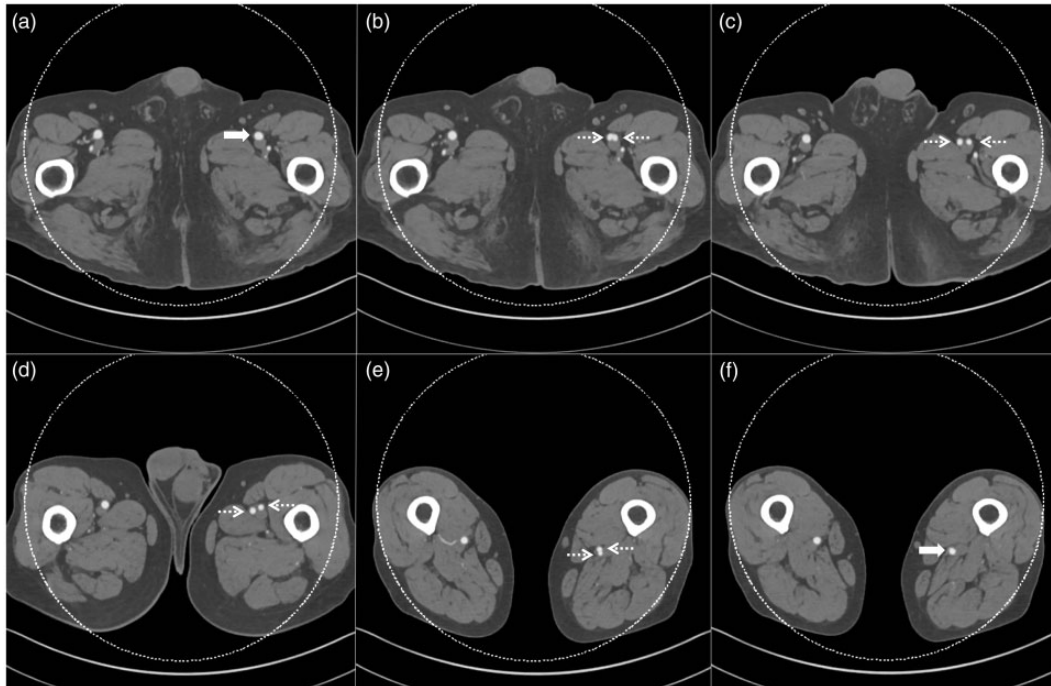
CTA of the lower limbs in the axial plane demonstrates duplication of the left SFA (dotted arrows) approximately 4 cm inferior to the CFA bifurcation. The duplicated SFA appears symmetrical in caliber although individually the vessel lumens are marginally smaller in caliber than the contralateral single right SFA. The duplicated SFA fused at the entrance of the adductor canal to form a single lumen vessel.
